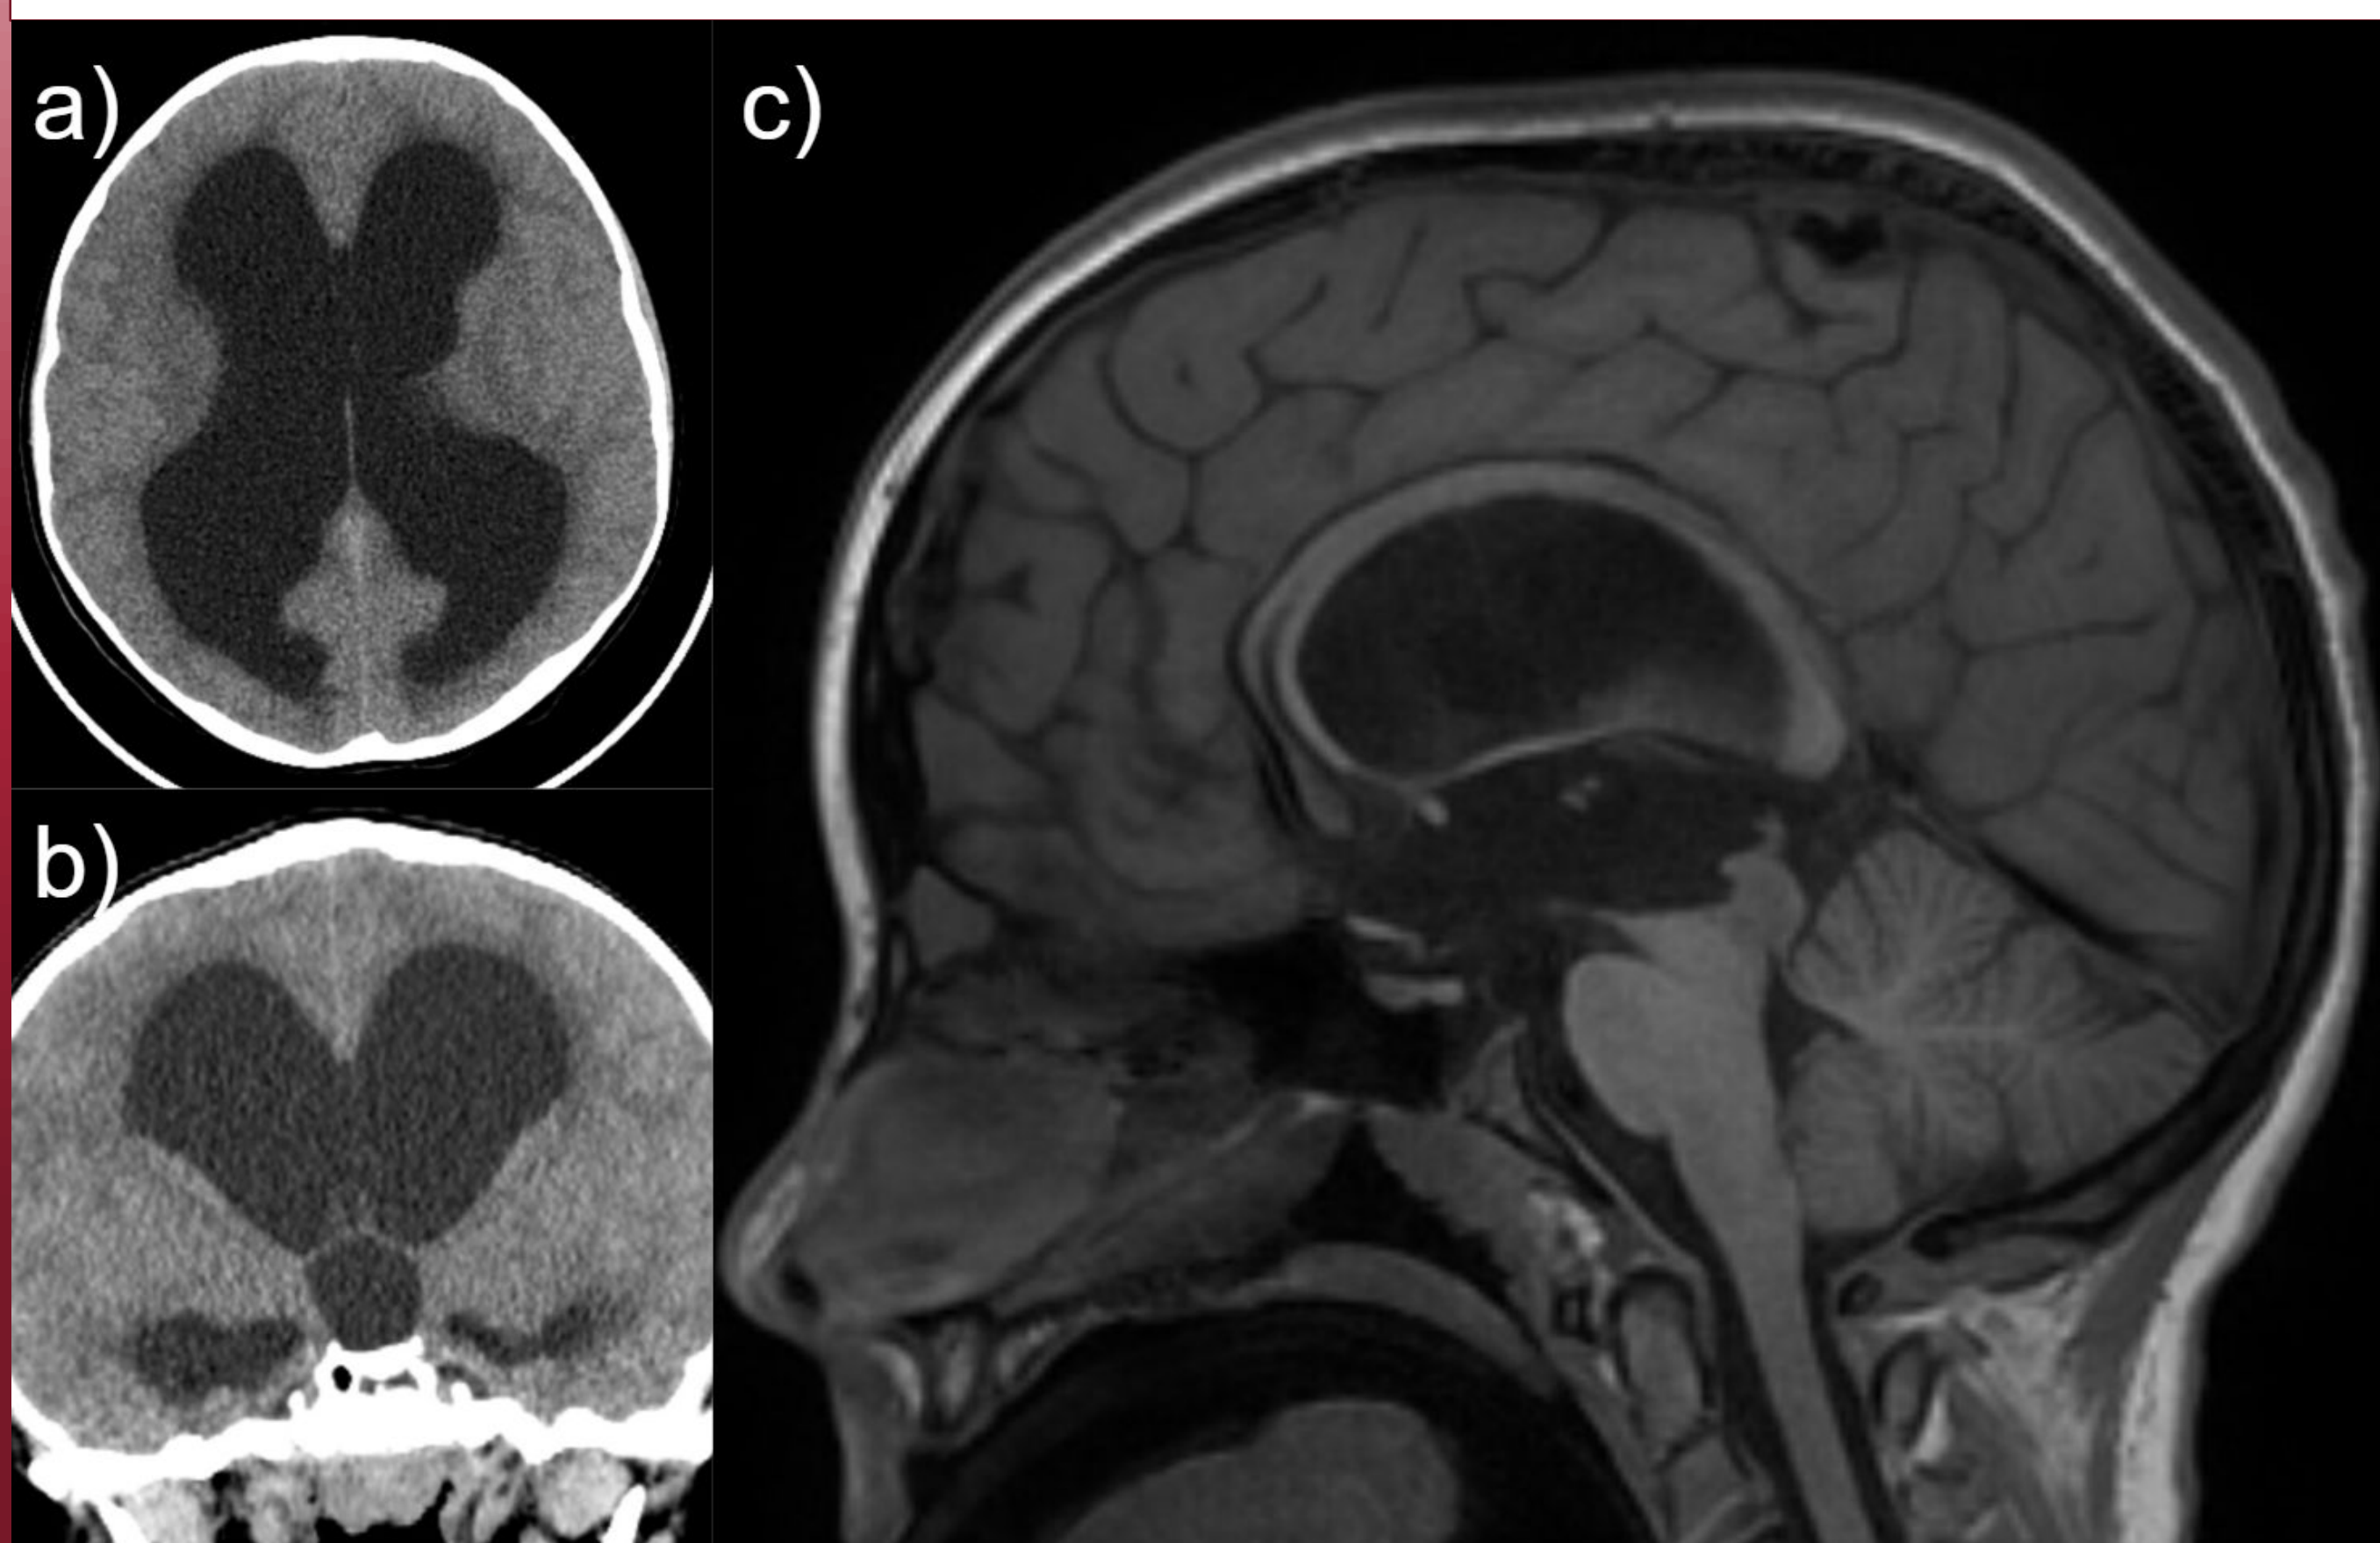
(A-b) non-contrast CT scan demonstrating chronic severe triventricular hydrocephalus in the axial and coronal planes, and (c) SPGR MRI demonstrating triventricular hydrocephalus in the sagittal plane.
